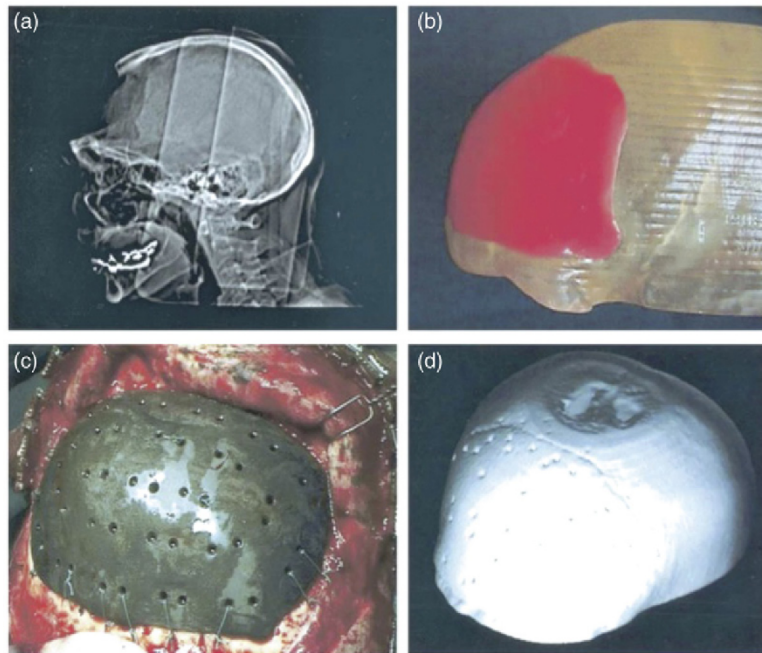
Cosmetic maxillofacial prosthetics can be customized to patient-specific defects and readily fabricated via stereolithography. (a) Digital scan of patient's large bifrontal defect; (b) model of patient skull fabricated via stereolithography and used as mold for implant generation; (c) patient-specific implant; (d) postoperative CT scan of implant showing excellent fit and integration with patient host [68].
